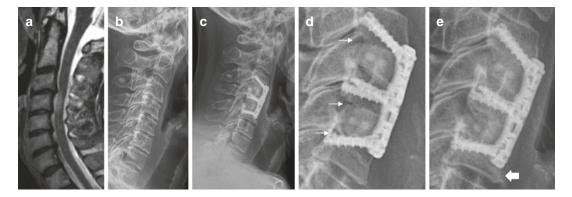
Sagittal T2-weighted MRI (a) demonstrating severe cervical stenosis at C3/C4 and osteophyte formation. Plain neutral lateral radiograph (b) demonstrating loss of cervical lordosis and multiple levels of cervical degenerative disease and disc collapse. The patient underwent a C3–C5 ACDF (c) with plate fixation. Bicortical screw purchase was obtained in the caudal vertebral body and subcortical in the cranial end of the construct. The
